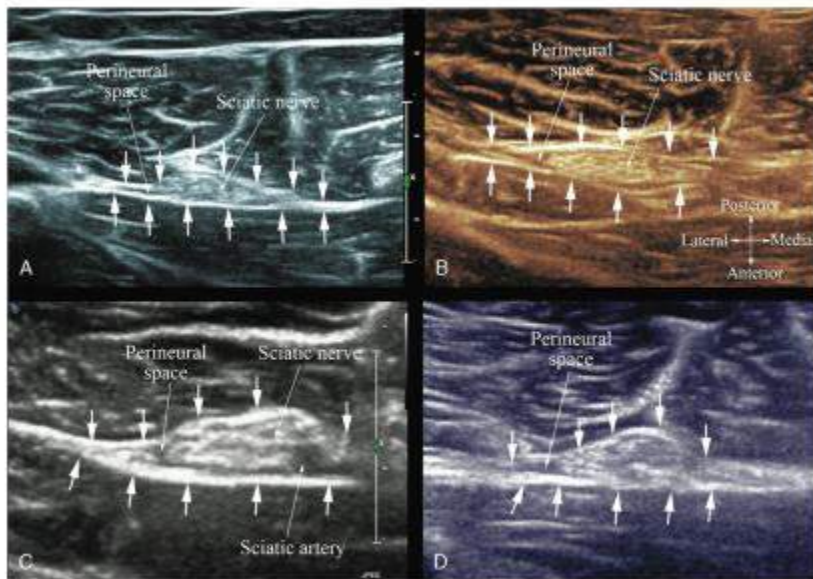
Transverse sonogram of the sciatic nerve from just above the apex of the popliteal fossa in the 4 patients. The sciatic nerve is seen as a hyperechoic structure within a narrow hypoechoic space (perineural space) between the hyperechoic epimysium (short white arrows) of the adjacent muscles. Note the sciatic artery anterior to the sciatic nerve in (C).
